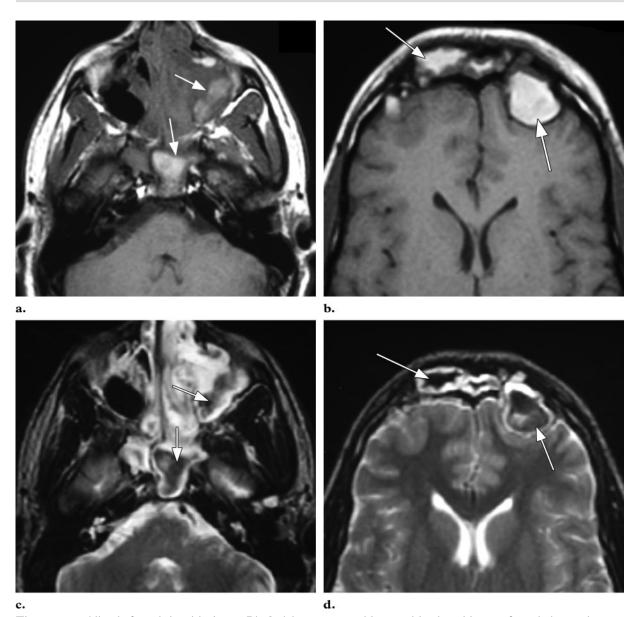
Allergic fungal sinusitis due to Bipolaris in a 22-year-old man with a long history of nasal obstruction (same patient as in Fig 9). (a, b) Unenhanced T1-weighted MR images show characteristic high signal intensity within the left maxillary, left posterior ethmoid, and sphenoid sinuses (arrows in a) and bilateral frontal sinuses (arrows in b). (c, d) Corresponding T2-weighted MR images show marked low signal intensity within the left maxillary, left posterior ethmoid, and sphenoid sinuses (arrows in c) and bilateral frontal sinuses (arrows in d).
